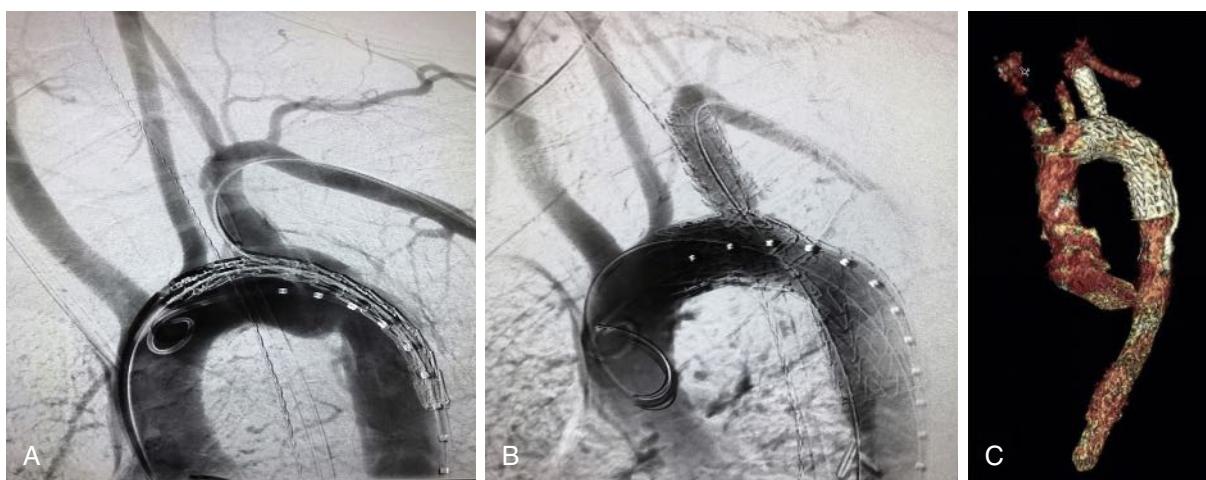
(A) Diagnostic and (B) completion angiography of a patient with a grade 3 blunt thoracic aortic injury treated with a GORE® TAG® Thoracic Branch Endoprosthesis (TBE). (C) Follow-up computed tomography angiography shows successful exclusion of the pseudoaneurysm.
